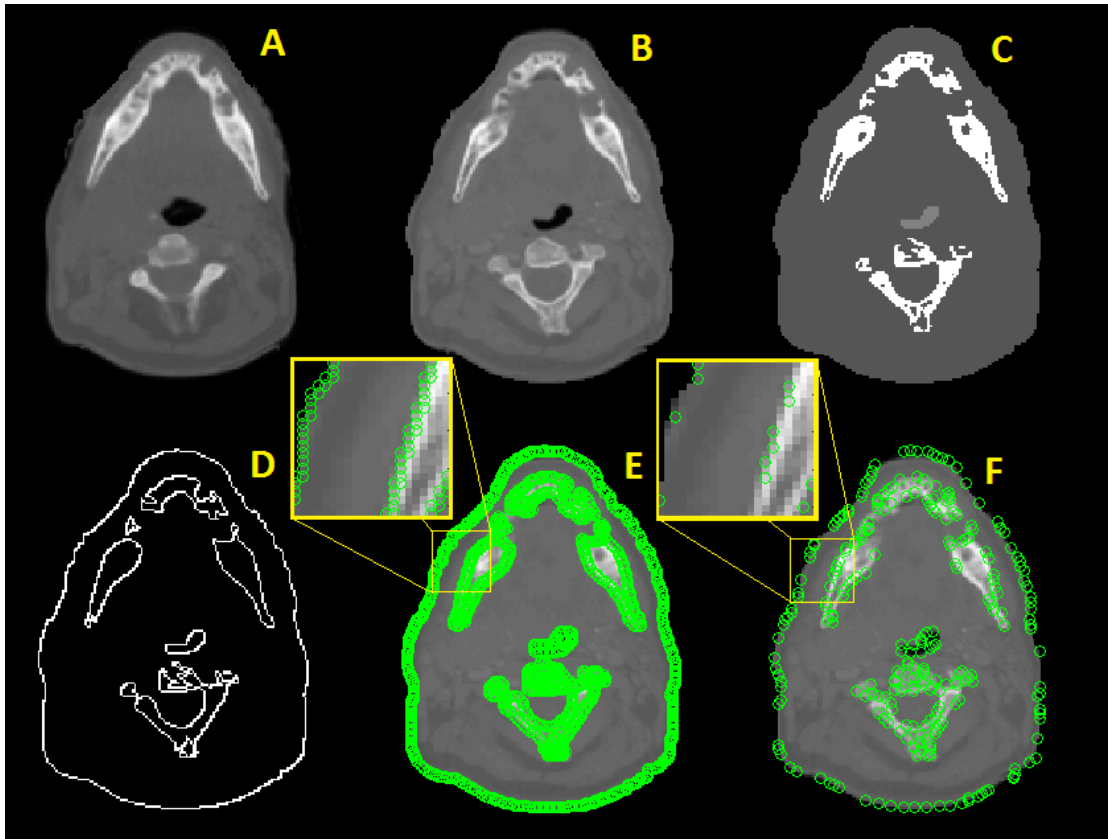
(A) Moving image (CBCT). (B) Static Image (CT). (C) Segmentation. (D) High gradient boundaries. (E) Initial set of landmarks with corresponding zoomed region. (F) Subset of stable landmarks with corresponding zoomed region.
